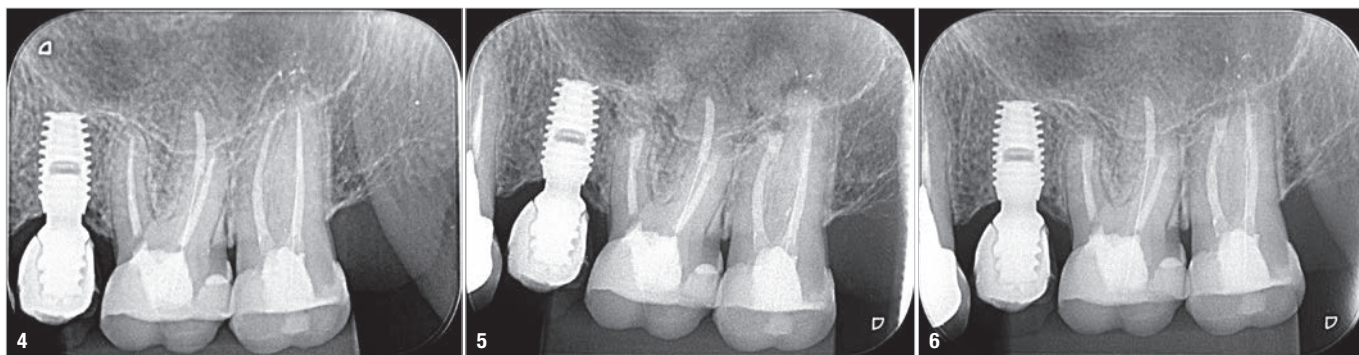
Pre-op radiograph. Fig. 5: Immediate post-op radiograph. Fig. 6: Four-month post-op radiograph.
